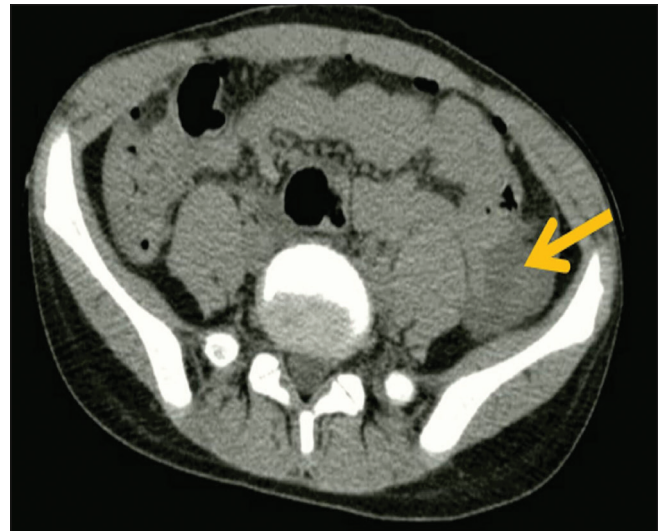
Axial view of contrast computed tomography scan: Free intra-peritoneal fluid is seen also in the left iliac fossa (yellow arrow)
